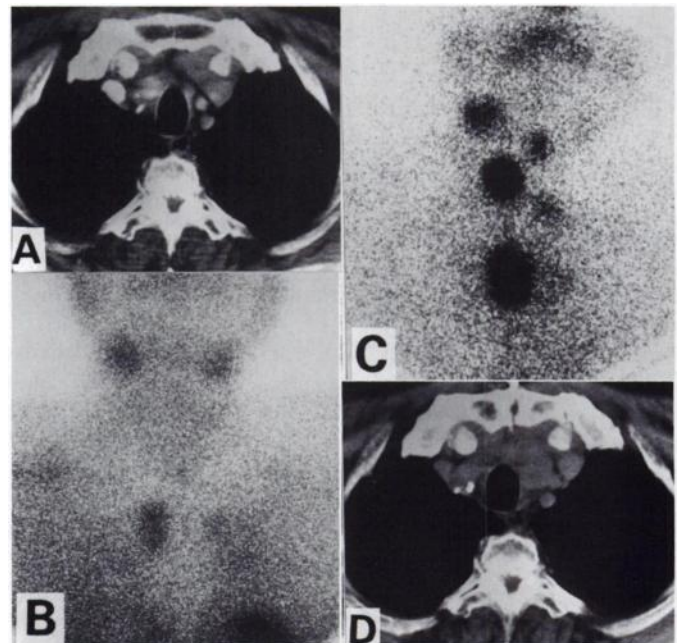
A 59-yr-old man with upper mediastinal lymph node metastasis from follicular carcinoma. (A) Pretreatment CT scan shows metastatic tumor. (B) Thallium-201 uptake in the tumor is high (T/B 2.45). (C) Iodine-131 scan shows good radioiodine uptake in the tumor. (D) However, post-treatment CT scan shows that tumor diameter has increased. The therapeutic outcome is ineffective.
